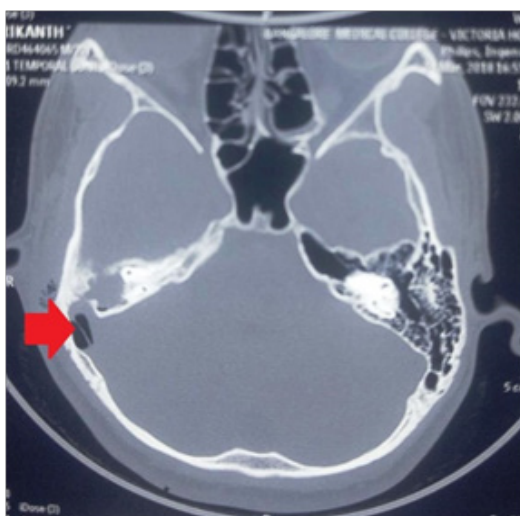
HRCT of the temporal bone showing pneumocephalus [arrow] on the right side.
